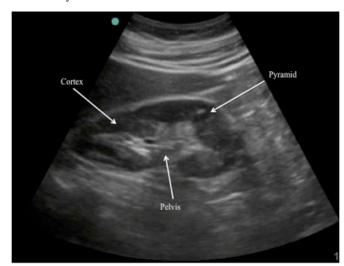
Ultrasound image of a normal right kidney.
